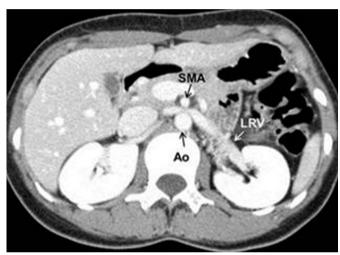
An computed tomography image. Contrast-enhanced computed tomography demonstrating compression of the left renal vein between the aorta (Ao) and superior mesenteric artery (SMA) with dilatation of the distal part of the left renal vein (LRV).
